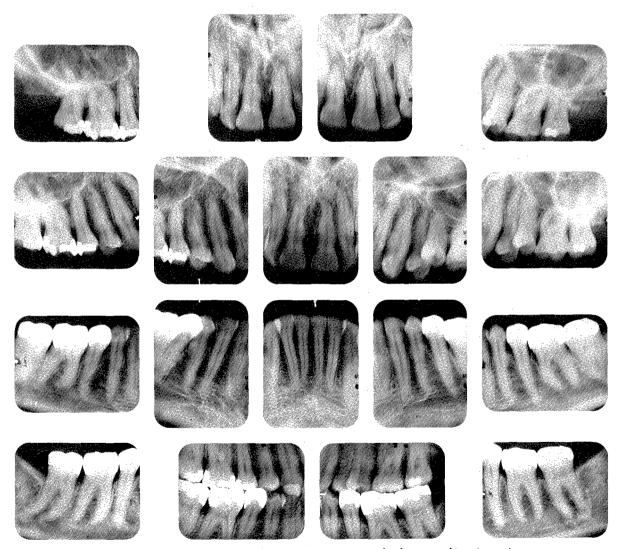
Good roentgenograms from a diagnostic and photographic viewpoint.
